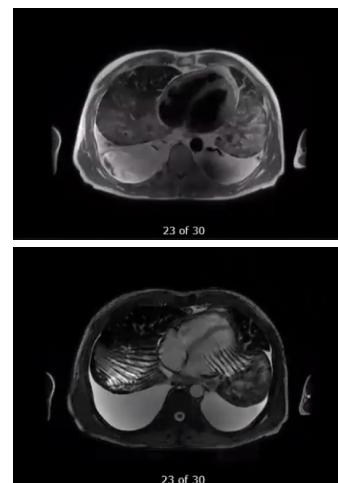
Single-shot fast spin-echo view (top) and Fast Imaging Employing Steady-state Acquisition view (bottom) on Cardiac MRI
